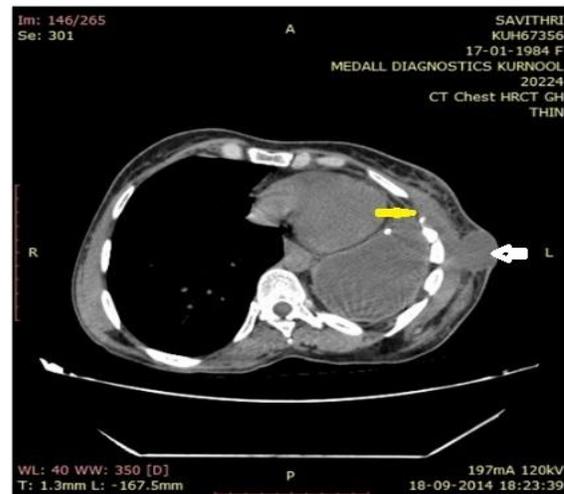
3:CT Chest revealing left empyema with communication to chest wall (yellow arrow), extra-thoracic swelling (white arrow), shift of mediastinum to left side, compensatory emphysema on right side.
